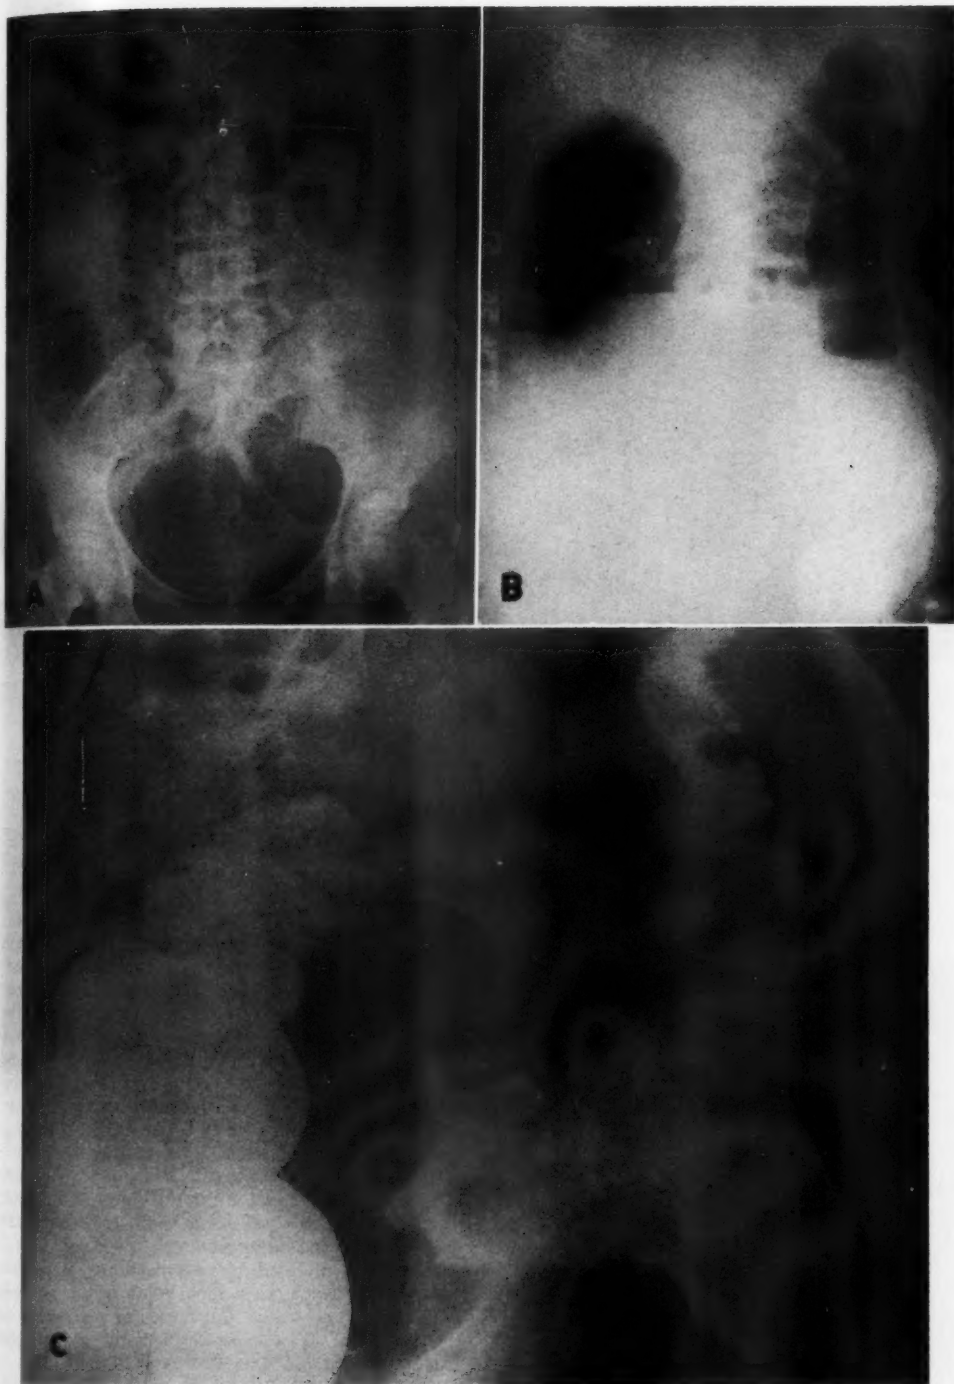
Case VI. A. Supine plain roentgenogram showing abnormal gaseous distention of colon. Small bowel also inflated.
